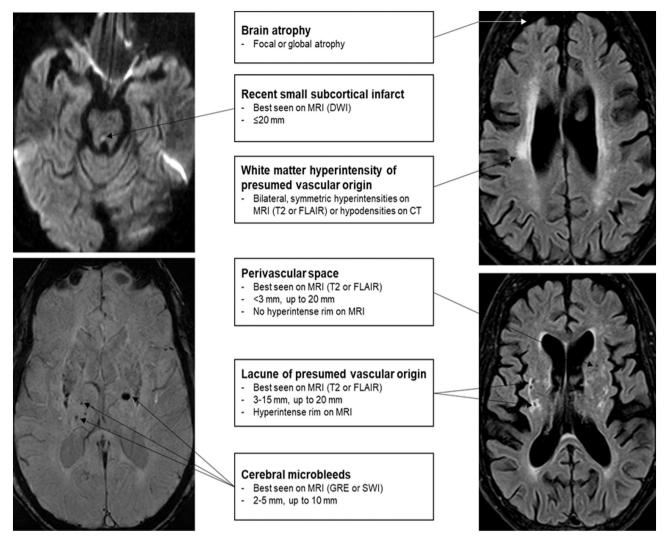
Neuroimaging features on MRI suggestive of cerebral small vessel disease in a 56 year old man with multiple vascular risk factors who presented with an acute lacunar stroke. DWI: diffusion-weighted imaging; FLAIR: fluid-attenuated inversion recovery; GRE: gradient-recalled echo; SWI: susceptibility weighted imaging.
